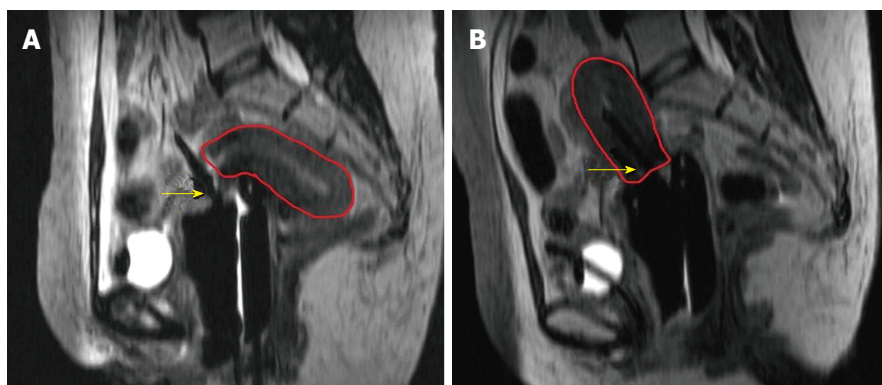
Uterine perforation despite perfect geometric applicator placement relative to bone anatomy. A: Shows the uterine perforation with retroverted uterus (red) diagnosed on magnetic resonance imaging (MRI) imaging for brachytherapy planning; B: Shows appropriate tandem placement (yellow arrow) ameliorated by placing the applicator under ultra-sound guidance and confirmed by MRI image-based planning.
